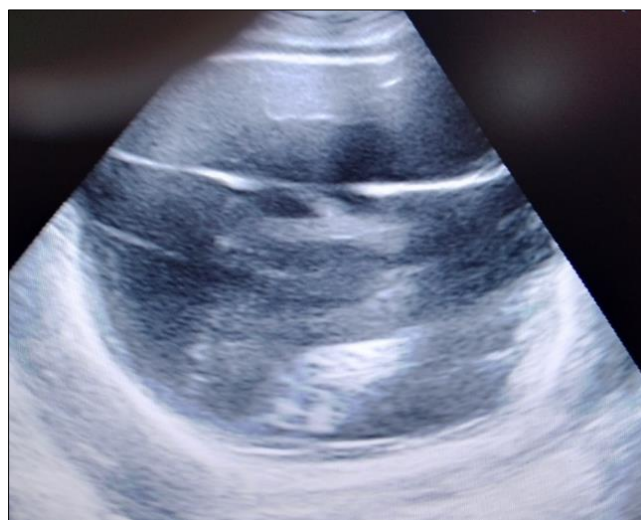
Sonogram from a parasagittal plane TFUS demonstrating fluid filled cranial cavity, absence of the cerebral hemispheres, centrally placed falx cerebri, hyperechoic basal ganglia tissue faintly demonstrated (inferior and lateral to the falx cerebri) and peripherally located echogenic skull vault
